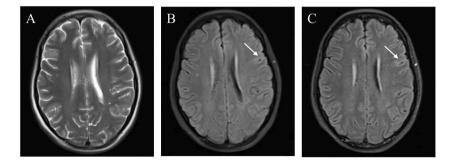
Cranial magnetic resonance imaging (plain scan + enhanced) at discharge: A. plain T2WI sequence, B. plain T2WI-FLAIR sequence: shows that the swelling of the brain parenchyma in the left frontal lobe is reduced (white arrow). C. enhanced T2WI-FLAIR sequence: shows that the degree of leptomeningitis in the left frontoparietal lobe is reduced (white arrow).
